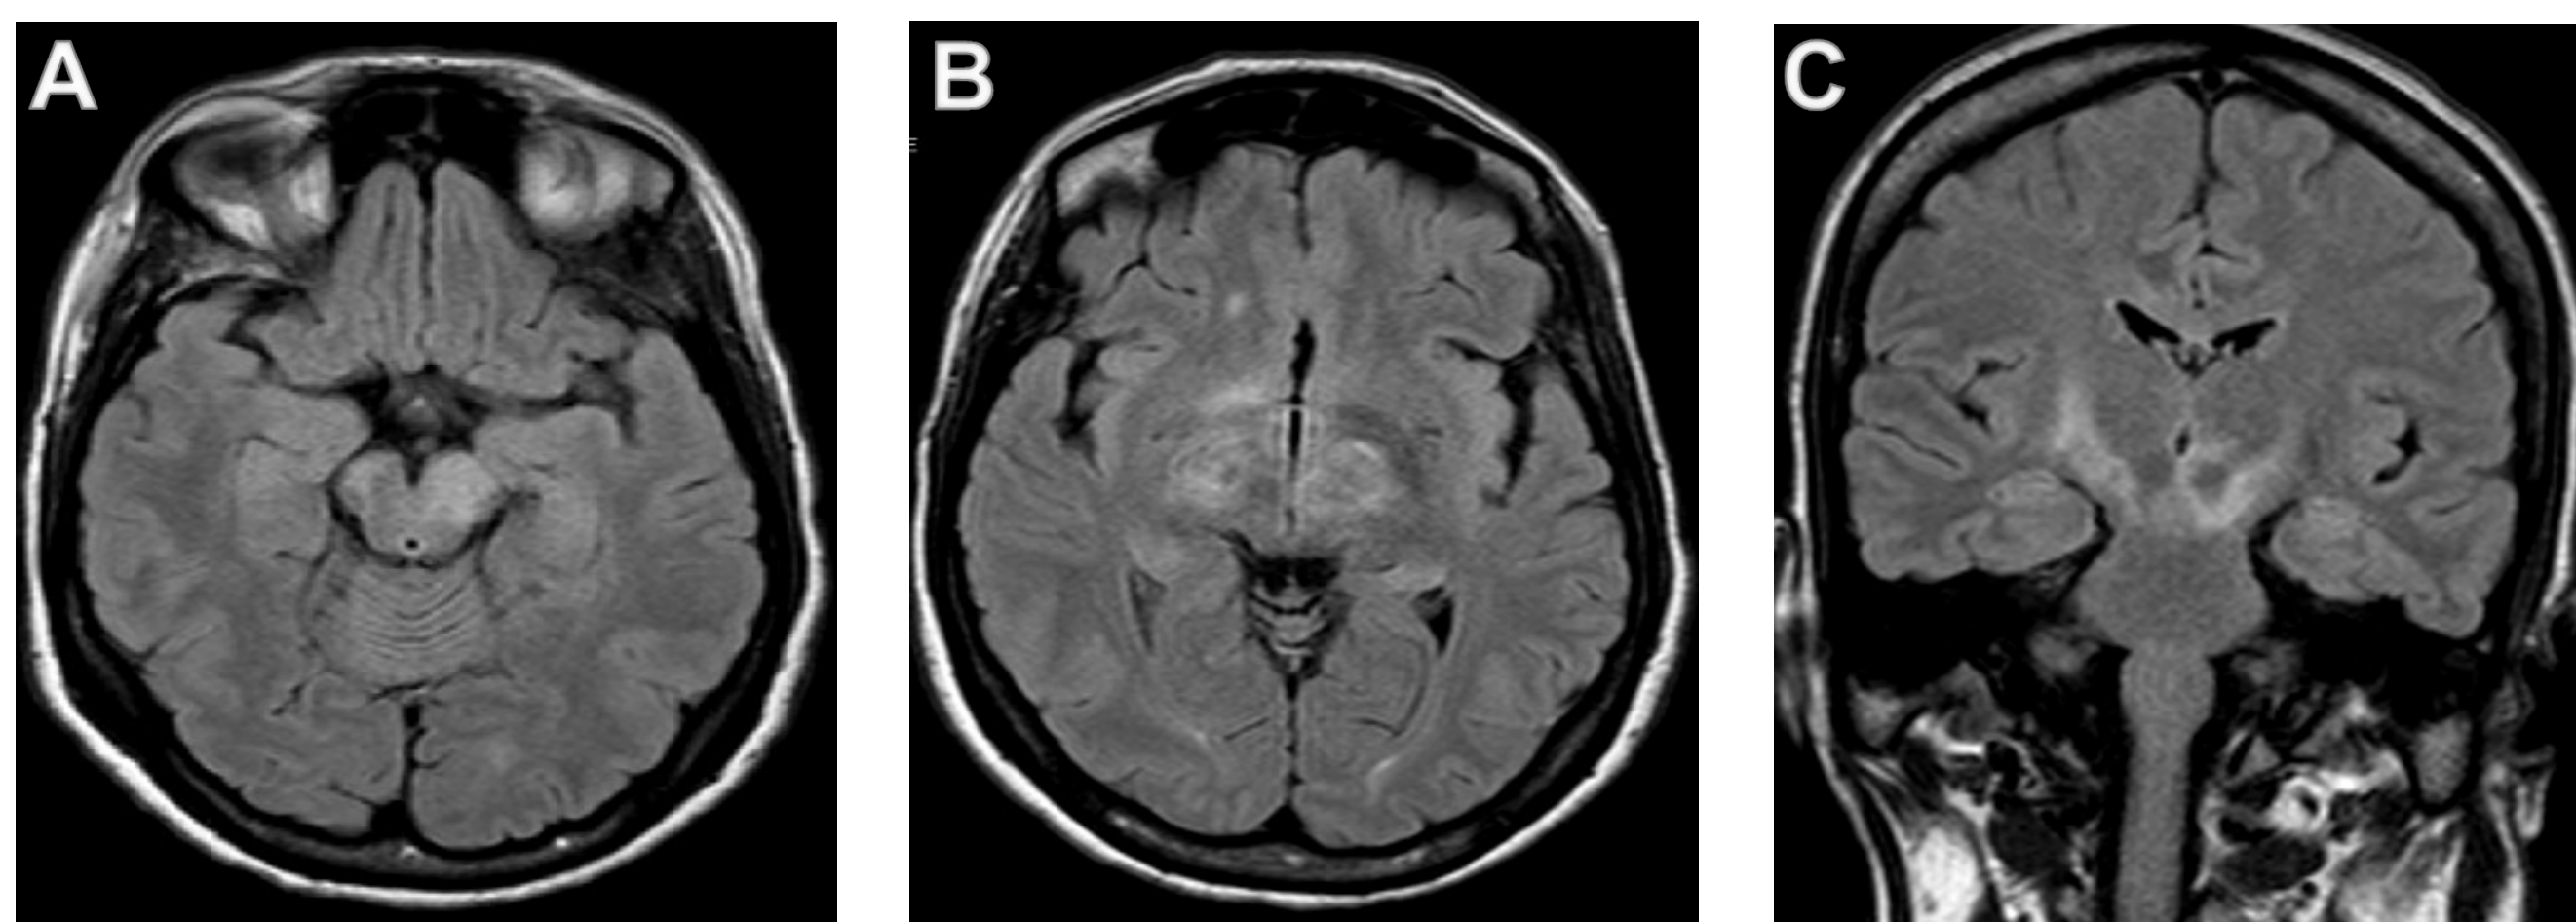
April 2016; Axial (A, B) and coronal (C) FLAIR MRI show hyperintense lesions in the left cerebral peduncle and in the right globus pallidus and posterior limb of the internal capsule.
